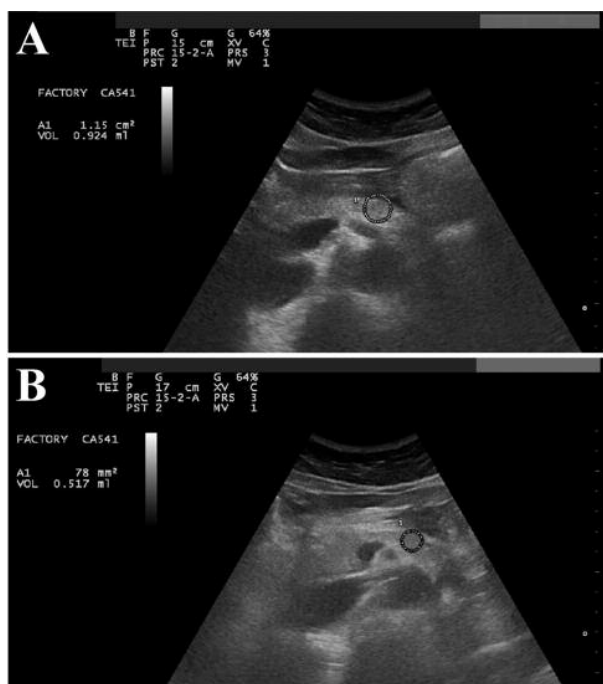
Ultrasonography of adenocarcinoma of the body of the pancreas before and after OA-GcMAF-based immunotherapy. These images refer to clinical case #1 and were taken before treatment (panel A), and after two weeks (panel B).
